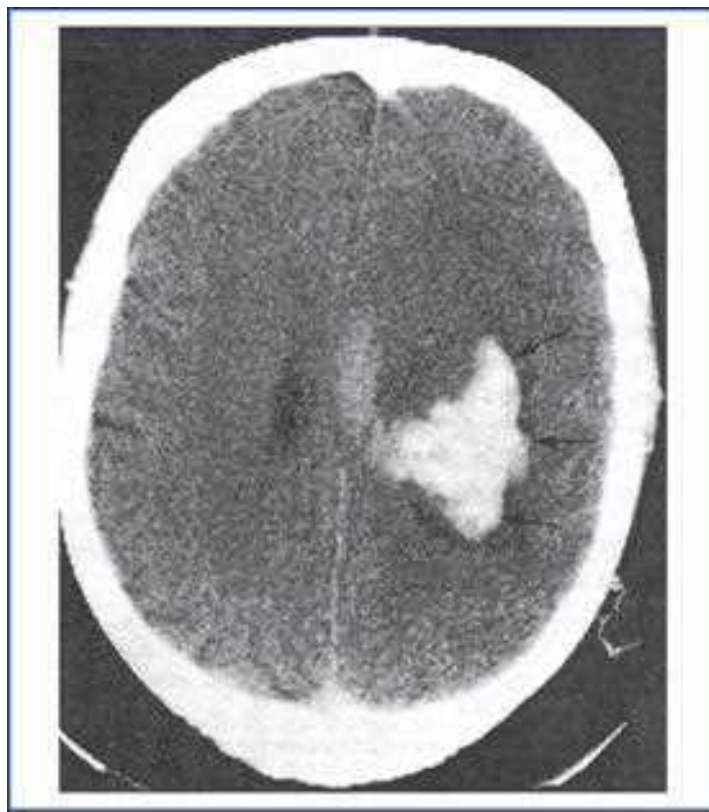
CT scan of brain showing intracerebral haemorrhage. (arrows) Source: Haslet, Christopher, Chilvers, Edwin R, Boon, Nicholas A, et al., editors. *Davidson's Principles and Practice of Medicine*. 19th edn. Oxford: Elsevier Science Ltd., 2002
